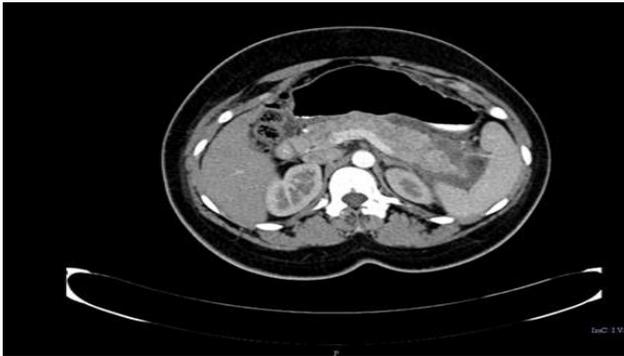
CT scan-bulky pancreas with peripancreatic fluid.
